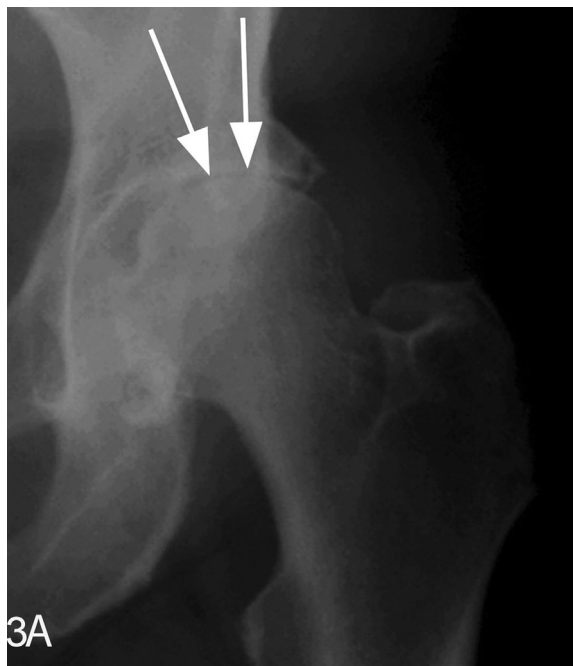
Radiograph of the hip joint shows superior JSN (arrows) without relevant osteophytes present.
